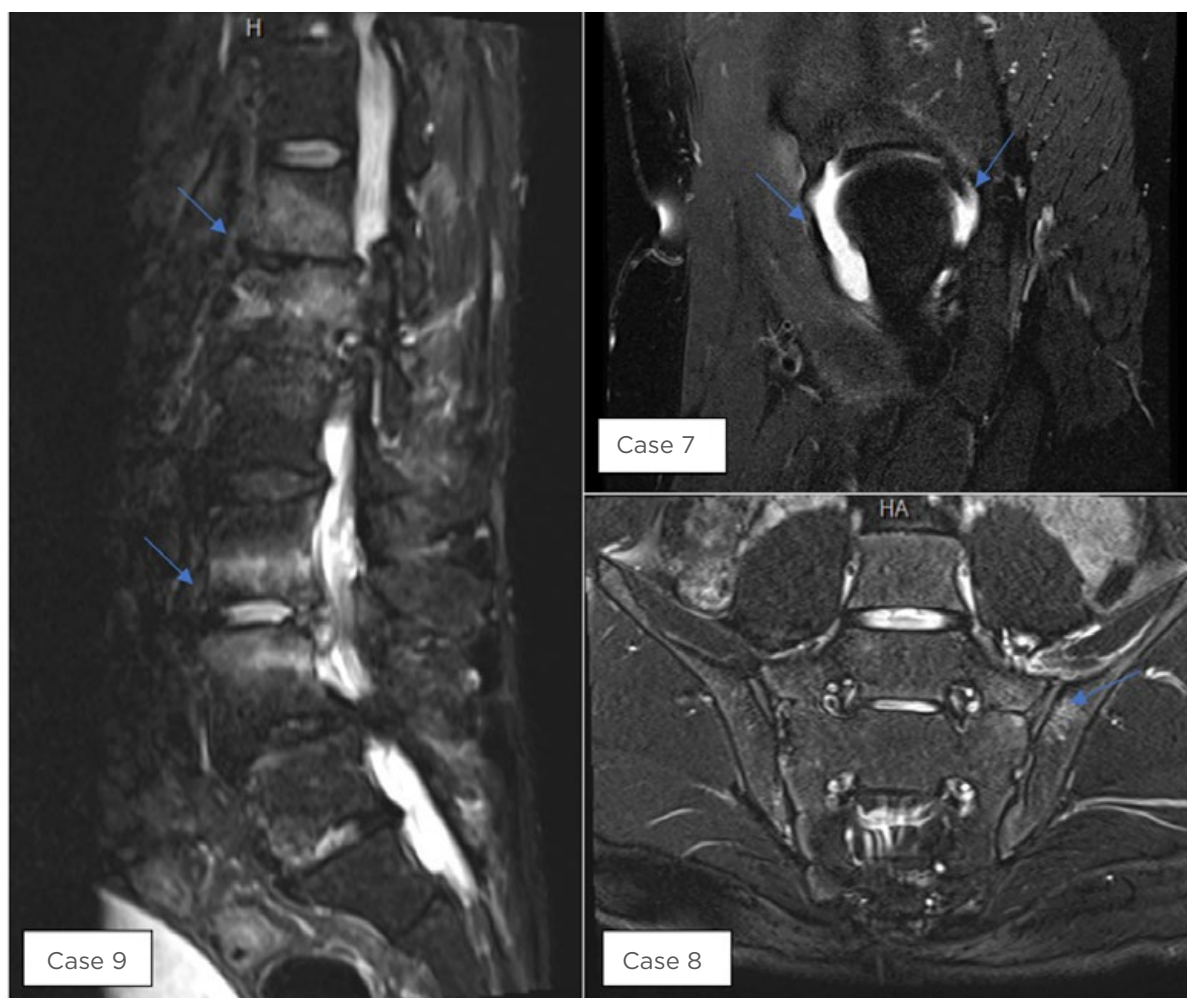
Positive MRI findings in selected cases as described in Table 2.
